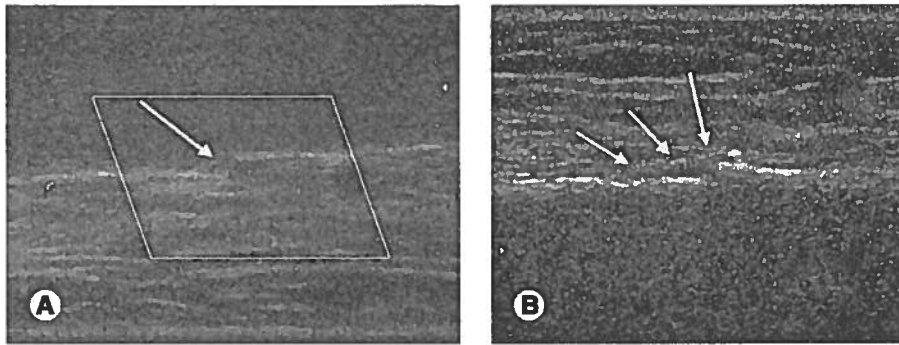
A) Transplant patient, radius at week 6. Color Doppler ultrasound shows no more vascularity close to the osteotomy site. (B) Ultrasound B mode performed at week 6. Longitudinal scan of the radius shows more delineated soft callus formation (arrows). (C) Conventional radiographs in anteroposterior and lateral projection at week 6 show no calcifications at the osteotomy site.
